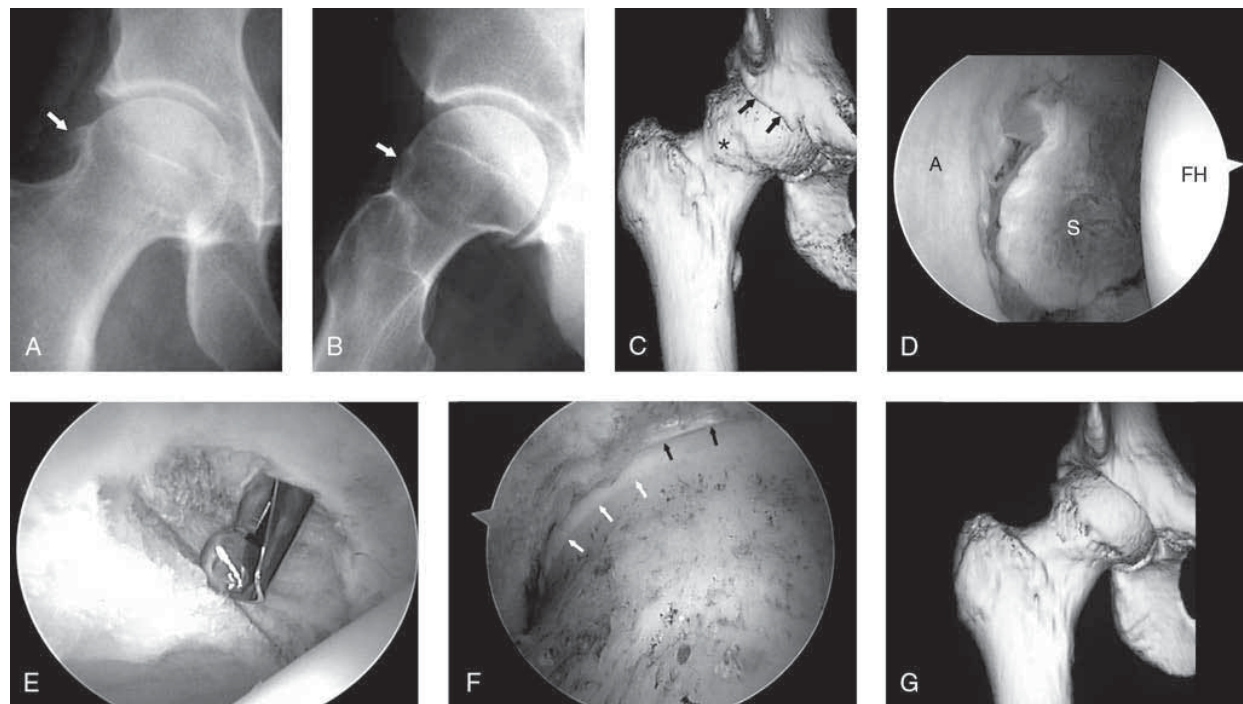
Imaging studies of the right hip of a 38-year-old woman with progressive pain and loss of motion. A, AP radiograph demonstrates acquired bony buildup/osteophyte formation on the lateral femoral head (*arrow*). B, A frog-leg lateral radiograph further defines the bony buildup on the anterior femoral head (*arrow*). C, A three-dimensional CT scan further defines the femoral head osteophyte (*) and the anterior acetabular lesion (*arrows*). D, Arthroscopy of the central weight-bearing surface of the joint demonstrates good articular preservation of both the acetabulum (A) and femoral head (FH), with some reactive synovitis within the fossa (S). E, The anterior acetabular osteophyte is excised. F, Viewing peripherally, the femoral head has been recontoured, showing the edge of the femoral articular surface (*white arrows*) and the labrum (*black arrows*). G, A postoperative three-dimensional CT scan demonstrates the extent of bony recontouring of both the acetabulum and femoral head. (Courtesy of J. W. Thomas Byrd, MD, Nashville, TN.)
